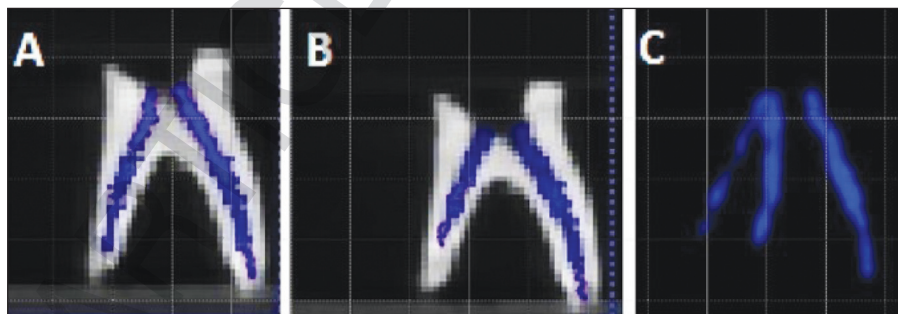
Cone-beam computed tomography image of volumetric filling in vertical plane.
